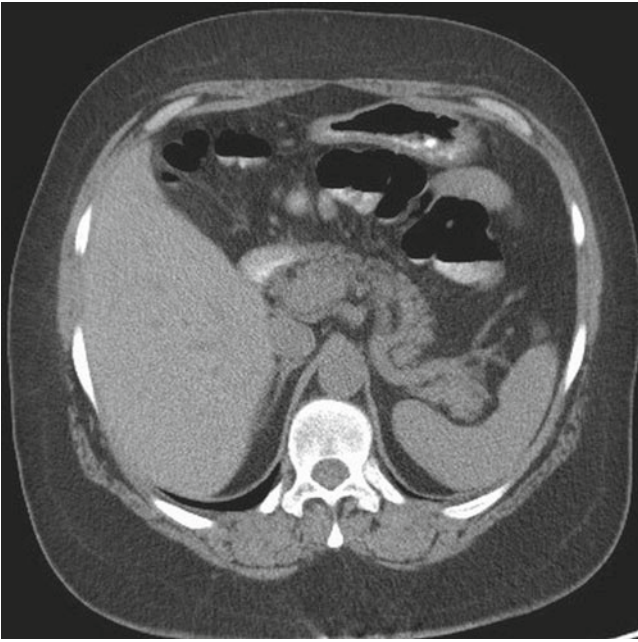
A 72-year-old woman with previous left nephrectomy on follow-up CT. Axial oral contrast enhanced CT image at the level of the pancreas demonstrates a normal pancreas. Diagnosis: Normal pancreas
